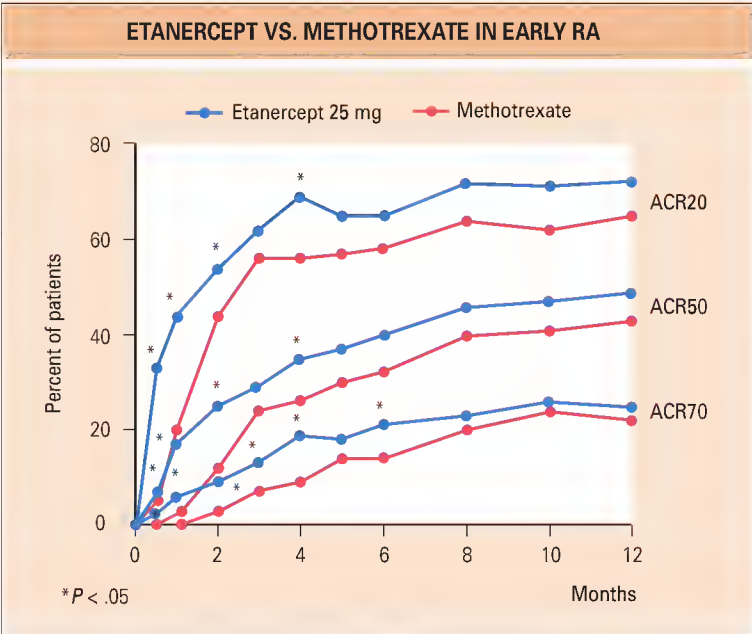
ERA trial: etanercept in early rheumatoid arthritis. (From Genovese MC, Bathon JM, Martin RW, et al. Etanercept versus MTX in patients with early rheumatoid arthritis: two year radiographic and clinical outcomes. *Arthritis Rheum* 2002;46:1443–50.)
